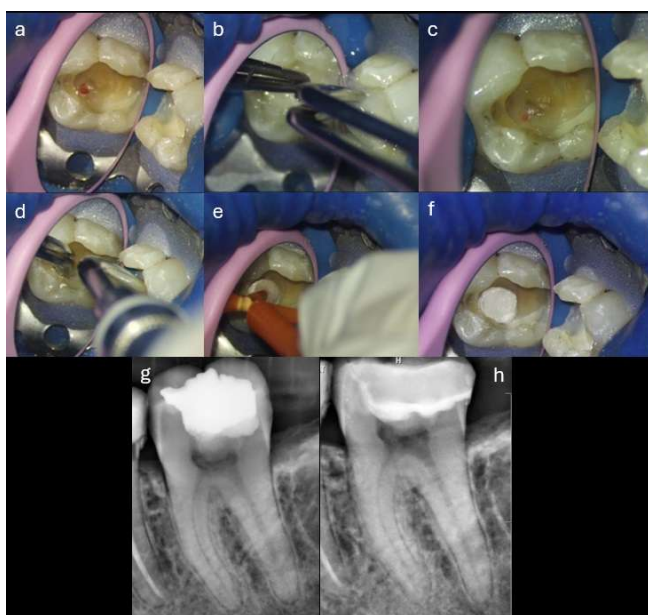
(A) Pulp exposure, (B) Hemostasis, w/ 3% NaOCl, (C) Confirmation of hemostasis and clean surface, (D) Placement of MTA using MAP VPT, (E) Gently condensation, (F) Confirmation of adequate placement, (G) Preoperative radiograph, (H) 8-month follow-up radiography
